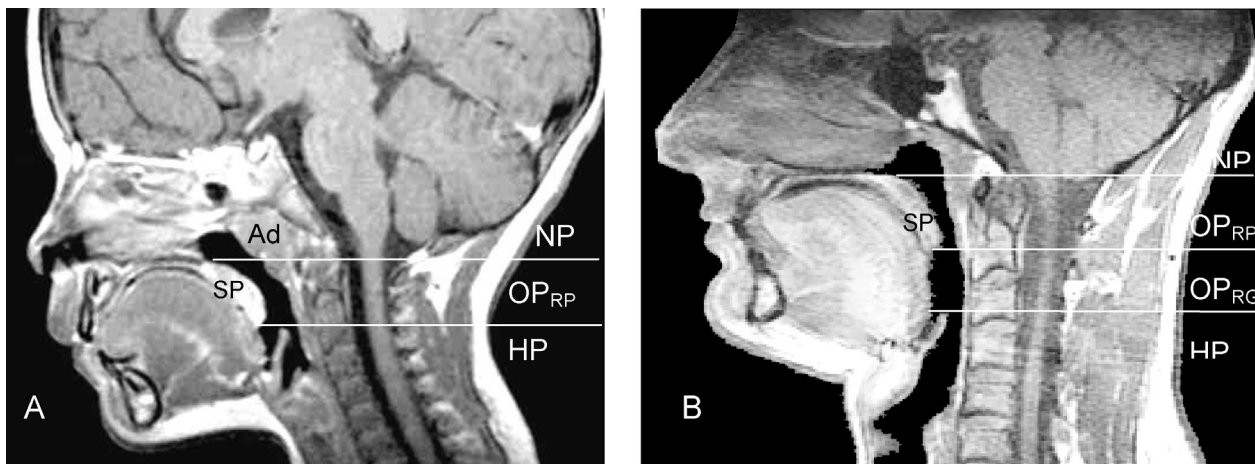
Anatomy of the pharynx. A mid-sagittal magnetic resonance image of the head and neck of a child (A) and an adult (B) are shown. The airway is shown in black. The radiographic anatomical regions of the upper airway in the child are the nasopharynx (NP), oropharynx adjacent to the retropalatal region (OP_{RP}), and hypopharynx (HP). The adult airway differs from that of the child by having, in addition, an oropharyngeal segment that is retroglottal (OP_{RG}). This anatomic difference is related to the descent of the larynx during the first 18 months of life. Ad refers to adenoid; SP, soft palate.
